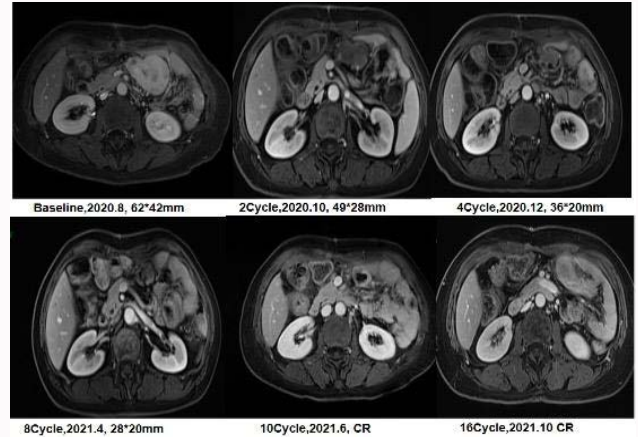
MRI scan before and after apatinib and celecoxib treatment showing PR and cCR.
